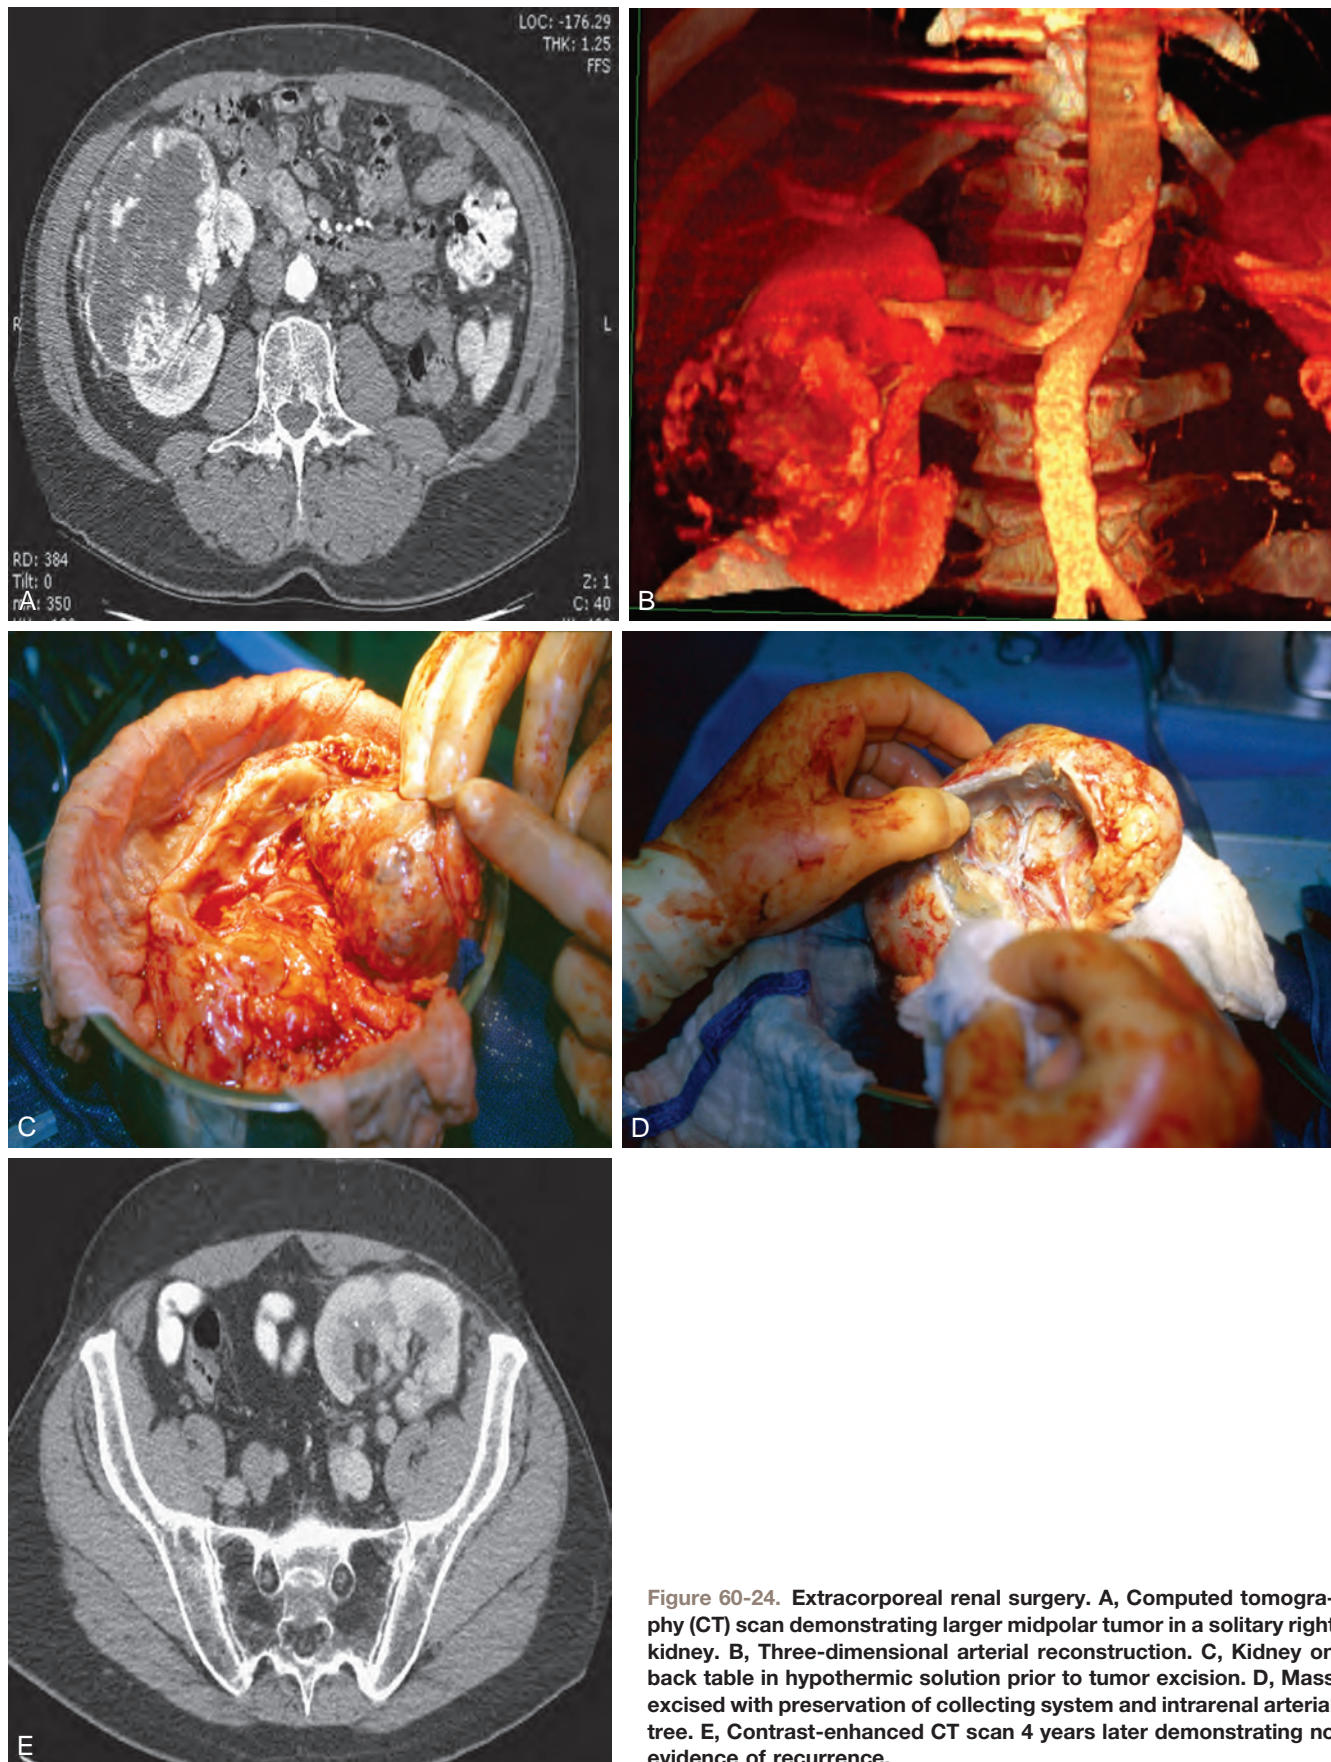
Extracorporeal renal surgery. A, Computed tomography (CT) scan demonstrating larger midpolar tumor in a solitary right kidney. B, Three-dimensional arterial reconstruction. C, Kidney on back table in hypothermic solution prior to tumor excision. D, Mass excised with preservation of collecting system and intrarenal arterial tree. E, Contrast-enhanced CT scan 4 years later demonstrating no evidence of recurrence.
